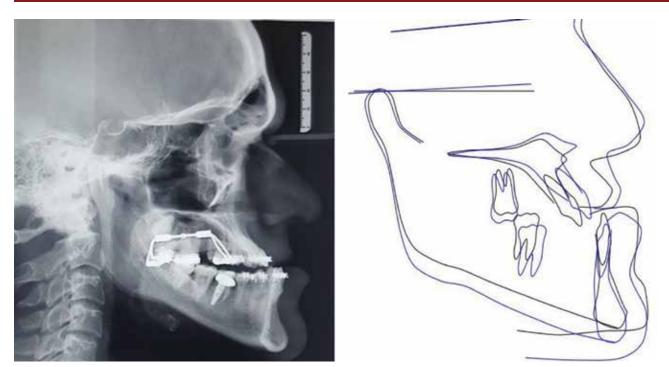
(a) Post distraction Cephalometric Radiograph (b) Superimpositions: pre-treatment (black) post-distraction (blue).
